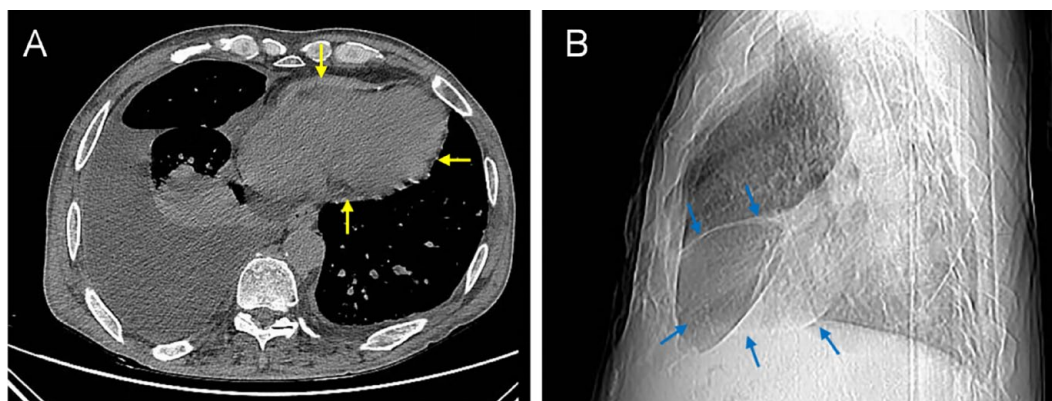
Computed tomography revealed increased pericardial thickness with calcification. Panel (A): Thickening and calcification of the pericardium (yellow arrow). Panel (B) Circular calcification of the pericardium (blue arrow).
